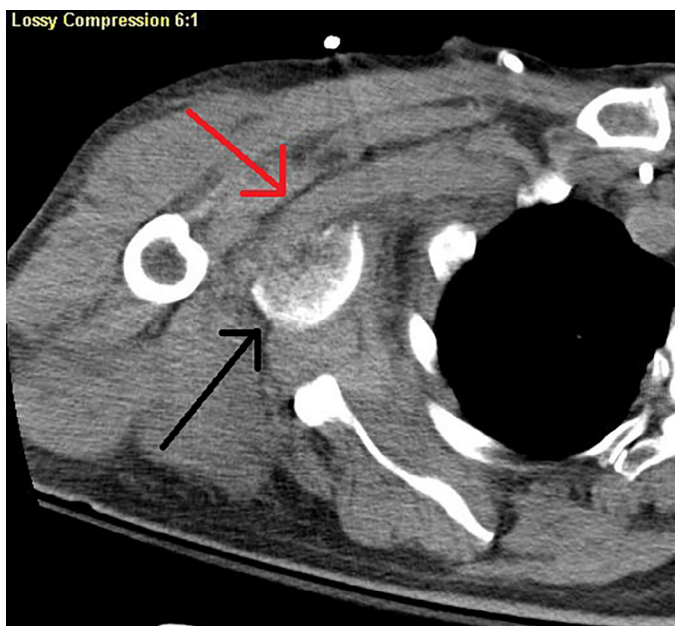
Axial computed tomography scan highlights the close proximity of the axillary artery (red arrow) and the humeral head fragment (black arrow).
